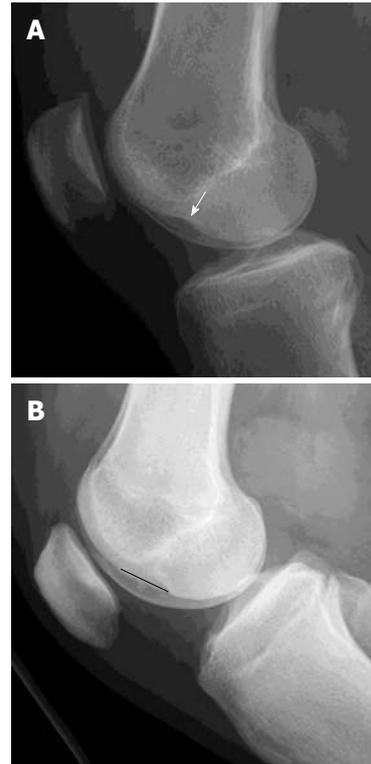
Osteochondral injury lateral femoral condyle. Lateral radiographs of two patients with complete anterior cruciate ligament (ACL) tear. A: Deep notch sign is abnormal deepening of the condylofemoral sulcus larger than 1.5 mm (white arrow); B: Long notch sign is abnormal lengthening of the condylofemoral sulcus (black straight line). These two signs are suggestive of osteochondral fracture of the lateral femoral condyle and highly associated with ACL tear though these are not very common findings.
